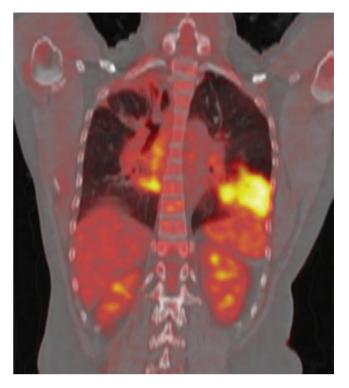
A coronal PET/CT image demonstrating metastatic lung cancer, evident as bright areas (in *yellow*) at the left base and the right hilum. The PET and CT images are aligned ("in register") to create precise anatomic localization of the heightened metabolic activity noted in the PET image. (*Reproduced with permission from Dr. Eduardo J. Mortani Barbosa, Jr.*)
